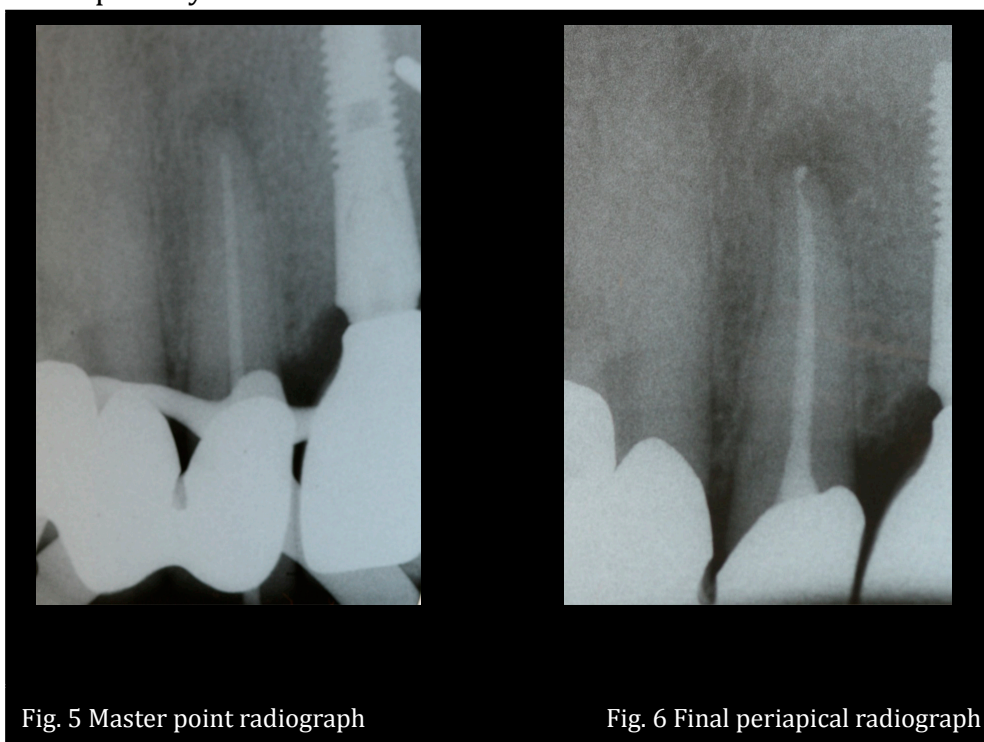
Master point radiograph
